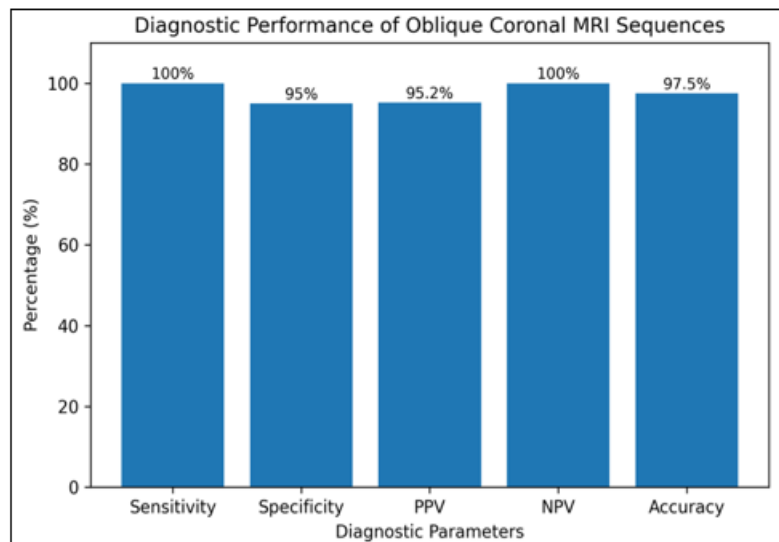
Graph depicting diagnostic Performance of Oblique Coronal MRI Sequences
